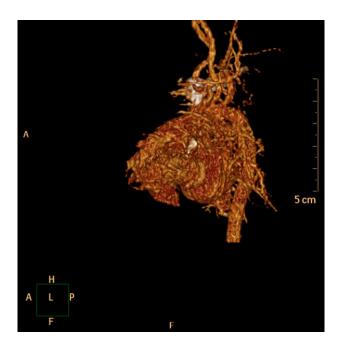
A meshwork of small systemic-to-pulmonary artery collaterals is noted to arise from ascending and descending aorta and arch arteries on this CT angiographic image with 3D reconstruction.
